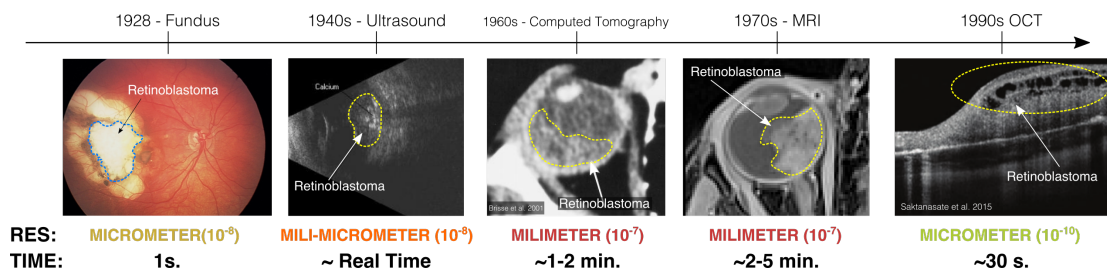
Evolution of multimodal imaging in ophthalmology : From left to right, Fundus image, Ultrasound, Computed Tomography, MRI (3T Scanner) and OCT scan. Past and present of ophthalmology for retinoblastoma. The year on top corresponds to the year that the image modality was first used to image the disease.
